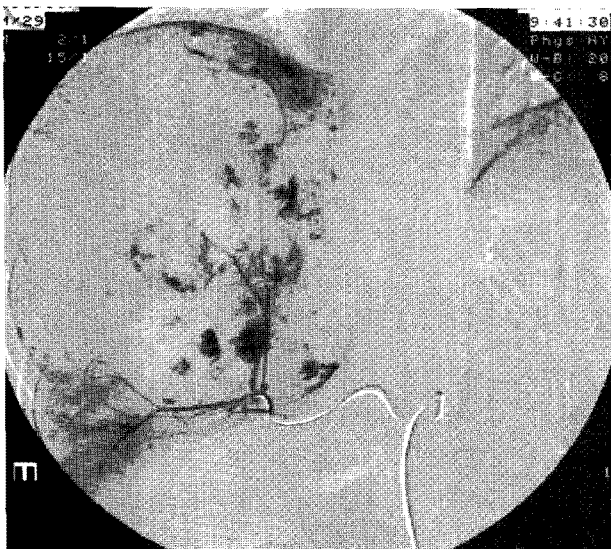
During hepatic angiography, a "cotton-wool" appearance was observed within the mass immediately after contrast injection, which is consistent with a giant hemangioma.⁵⁾ Embolization with Ivalon was performed.⁶⁾ The etiology and pathogenesis of KMS remain largely undetermined. KMS has highest incidence in infants, usually during the first few weeks of life,¹⁾ but it may also appear later.⁷⁾ Various diagnostic procedures have been used to establish the presence of a hemangioma.^{8,9)} However, Tc-99m RBC scintigraphy and SPECT have been proven to be cost effective and reliable diagnostic methods for confirming or excluding the presence of hemangioma.¹⁰⁻¹²⁾ Total body blood pool imaging studies performed during RBC scintigraphy are useful for detecting or excluding occult hemangiomas in other parts of the body.^{13,14)} This report describes a patient with giant hepatic hemangioma complicated with KMS who underwent a total body blood pool imaging study in addition to regular RBC scintigraphy and SPECT.
